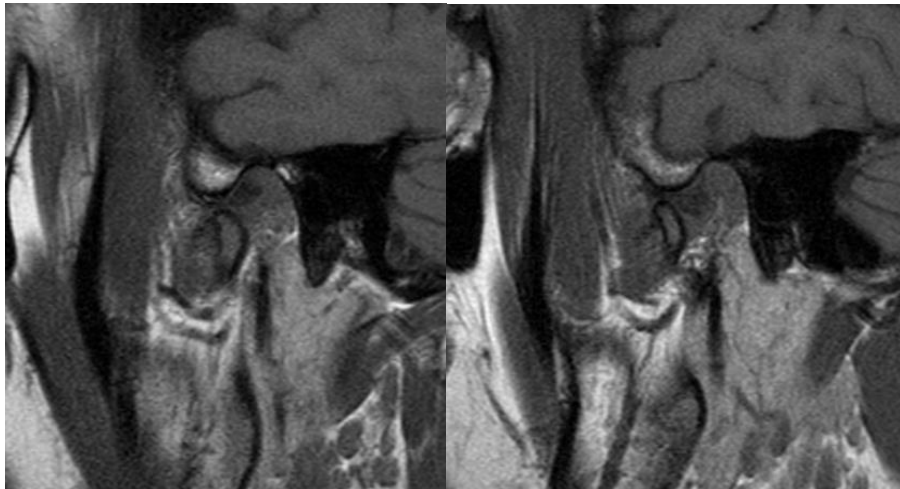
Post-Treatment Sagittal T1 Weighted MRI in open mouth position of right (a) and left (b) TMJ show normal 'Bow-Tie' appearance suggesting disc reduction
